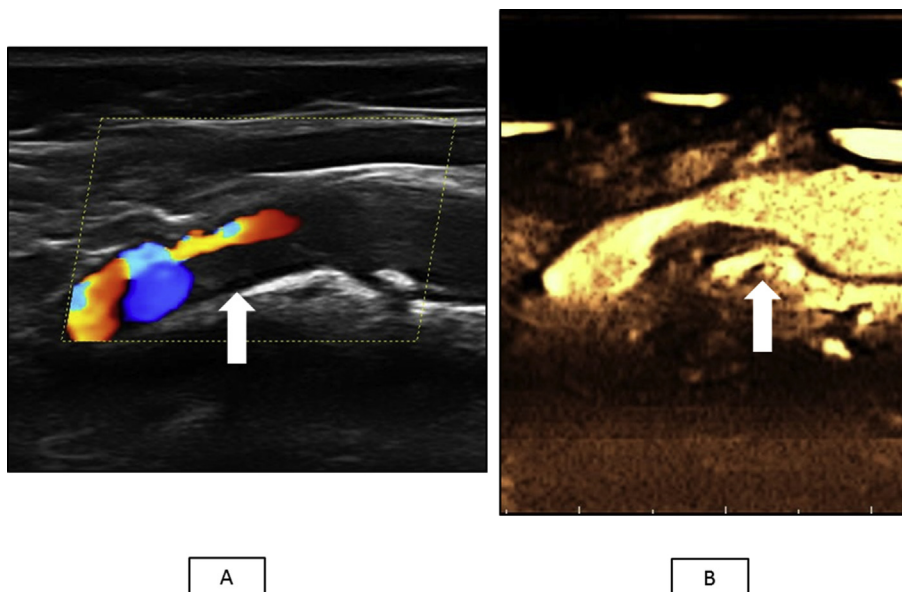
(A) Color Doppler ultrasound examination of severe left ICA stenosis with Type I (uniformly echolucent) plaque. (B) Contrast enhanced ultrasound examination showing microbubbles confined to the shoulder and/or adventitial side of the plaque (Grade 1).
